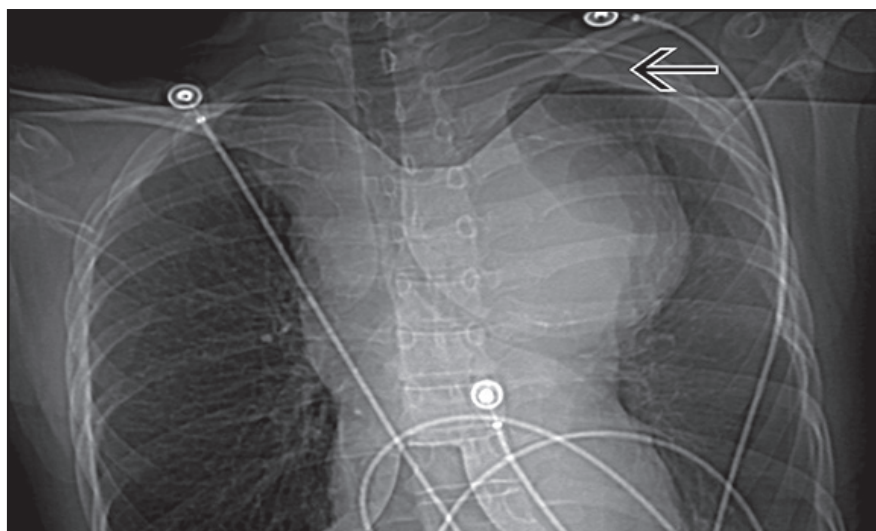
CT survey image shows a large round mediastinal mass depressing the left mainstem bronchus. There is an apical cap (arrow) and diffuse increased density of the left hemithorax due to layering hemothorax.
